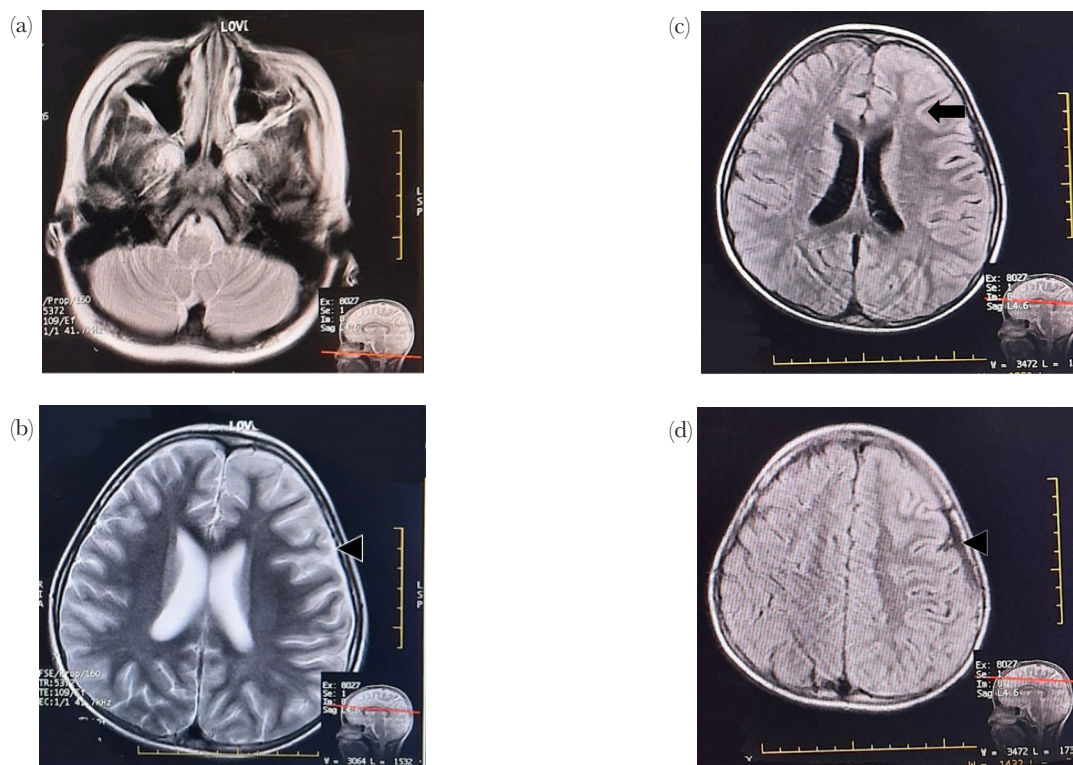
The T2 weighted axial magnetic resonance image of the head shows mucosal thickening in maxilla sinus (arrow) (a) and hygroma subdural in left temporoparietal (arrowhead) (b). The axial FLAIR magnetic resonance image shows no infarction in the left frontal lobe (arrow) and thin hygroma subdural in the left temporoparietal (arrowhead) (c,d)
